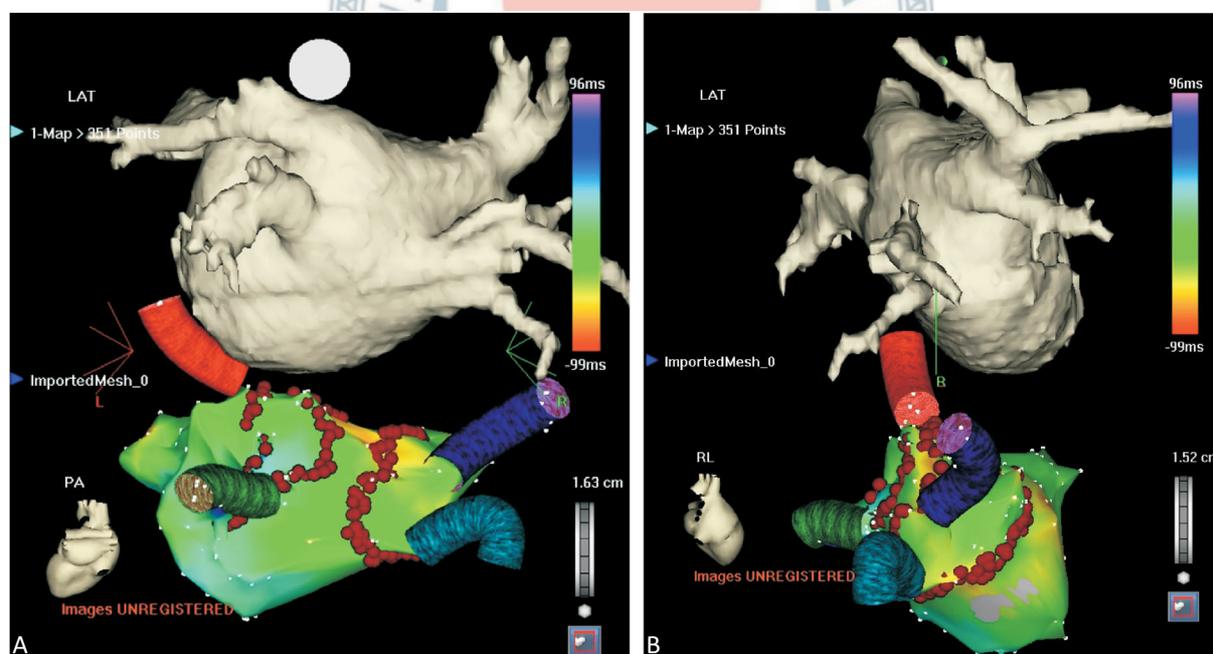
Depicted our ablation strategy for atrial fibrillation. We did three-dimensional electroanatomic mapping by using CARTO XP[®] system (Biosense-Webster, California, USA) with the assistance of integrated cardiac multi-slice computed tomography images (A and B, upper panel: volume rendering computed tomography images of left atrium; lower panel, CARTO mapping; A posterior anterior view, B right lateral view). After mapping the anatomic structure and electric signals of left atrium, circumferential pulmonary vein isolation was performed using irrigation catheter (ablation points denoted by red dots).
